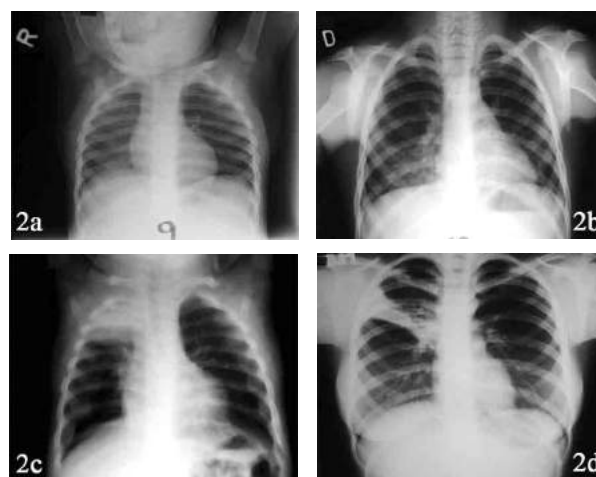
Chest X-ray findings in children with unrecognized foreign body aspiration: hyperinflation of the left lung (a), right-sided pneumonia paracardially and basally (b), atelectasis of the right upper lobe (c - complete, d - segmental)
